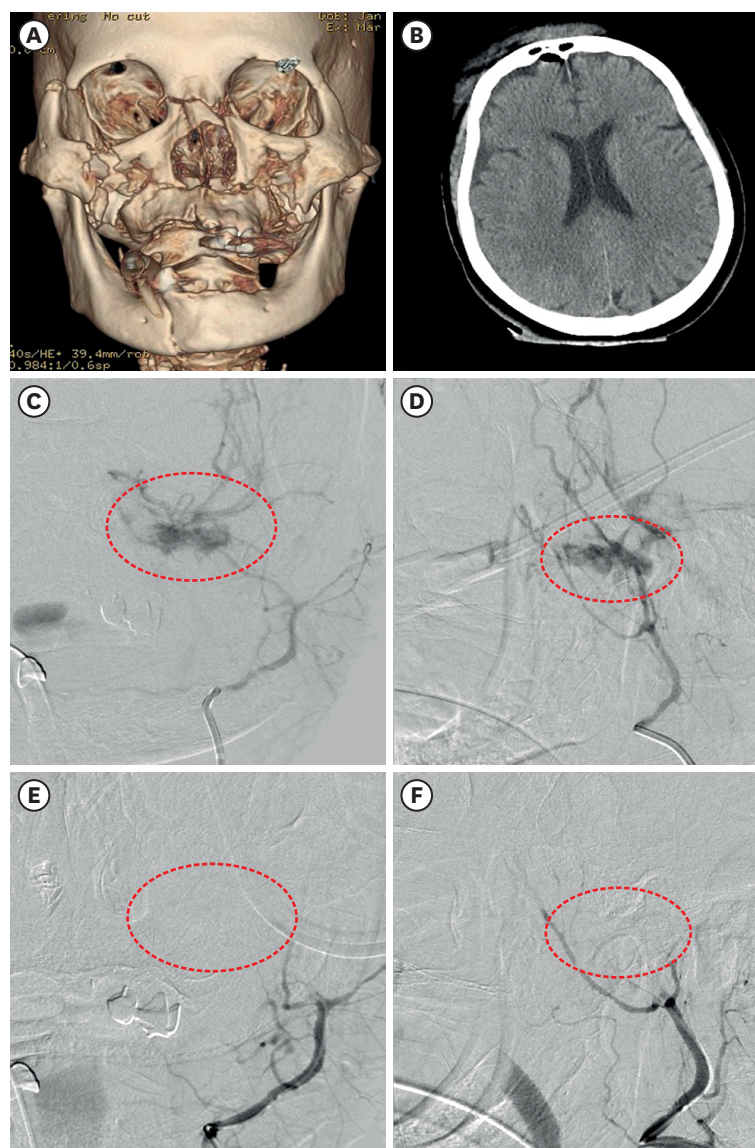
A 77-year-old female was transferred to our institution with decreased consciousness, active oronasal bleeding, multiple facial laceration and facial deformity after a fall from 5 meters high. (A) 3D reconstruction image of facial CT and (B) brain CT showed multiple facial bone fractures and pneumocephalus without traumatic intracranial hemorrhage. (C) AP and (D) lateral views of selective angiography of left ECAs showed contrast extravasation in the distal branches of the IMA. After embolization of the left IMA with PVA particles (a range of particle size, 250–350 microns), (E) AP and (F) lateral view of the left ECA angiography demonstrated disappearance of the extravasation in the distal branches of the left IMA. Red-dot circles indicate the extravasation and disappearance of the extravasation. CT: computed tomography, AP: anterior-posterior, ECA: external cerebral artery, IMA: internal maxillary artery, PVA: polyvinyl alcohol.
